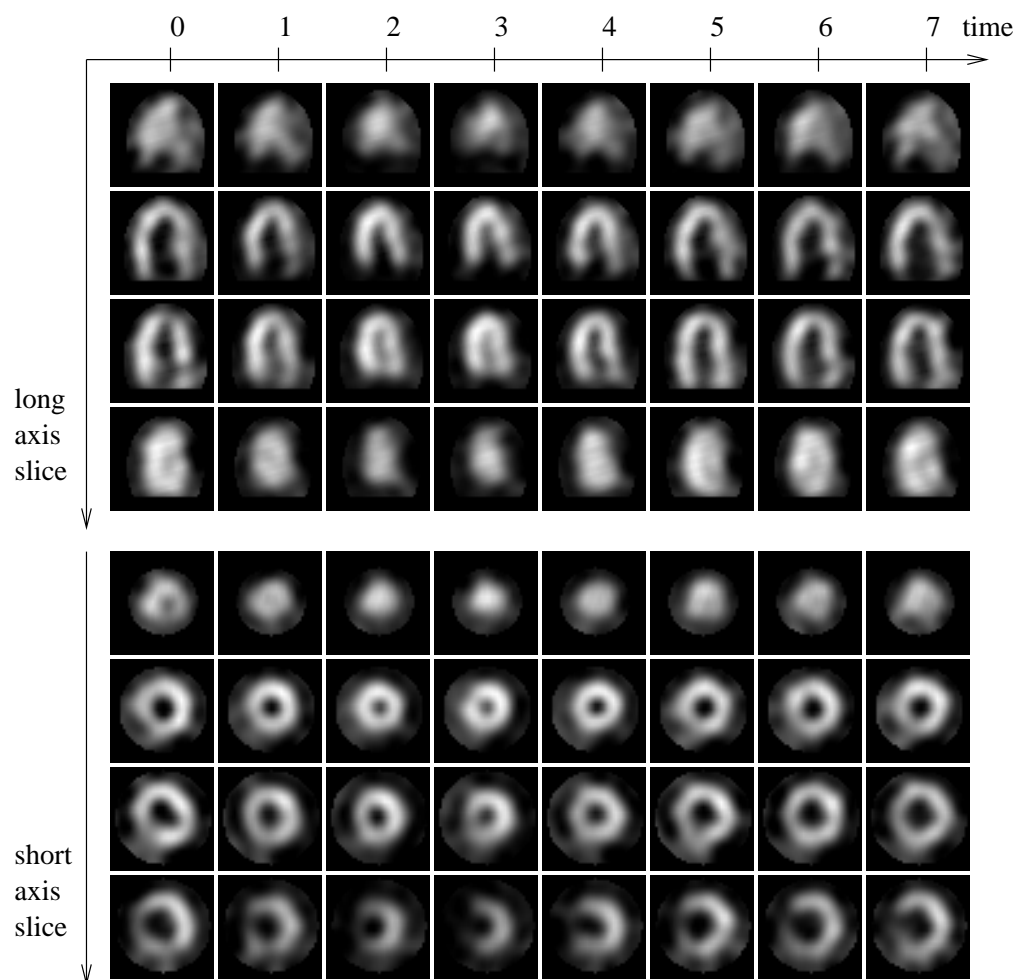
SPECT images used to build the 4D reference model. Top row: 4 long axis slices visualized at the height time instants. Bottom row: 4 short axis slices visualized at the 8 time instants.
